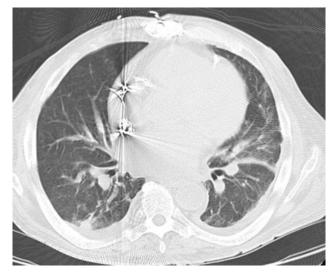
Computed tomogram, taken 4 weeks after discharge, consistent with resolving pulmonary disease.
